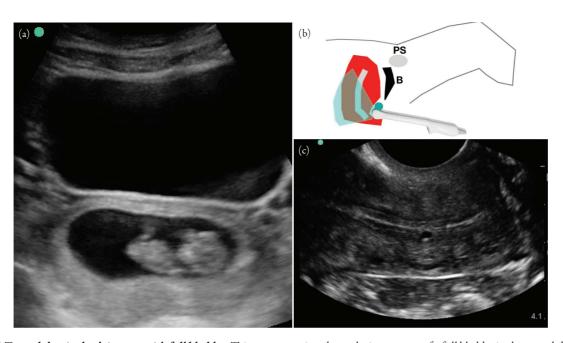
(a) Transabdominal pelvic exam with full bladder. This transverse view shows the importance of a full bladder in the transabdominal window. The ultrasound beam is able to pass through the fluid-filled bladder to image the intrauterine pregnancy just posterior to the bladder. With an empty bladder, air-filled bowel will surround the uterus, and shield it from ultrasound visualization. (b) Transvaginal pelvic exam with empty bladder. In the top panel, the decompressed bladder (B) lies just superior-posterior to the pubic symphysis (PS), allowing the uterine body and fundus to be closer to the transducer. The indicator is pointed anteriorly, so that the left of the screen is also directed anteriorly. Because of this orientation, the uterine body and endometrial stripe are imaged perpendicular to the ultrasound beams (bottom panel, c), allowing for better resolution.
